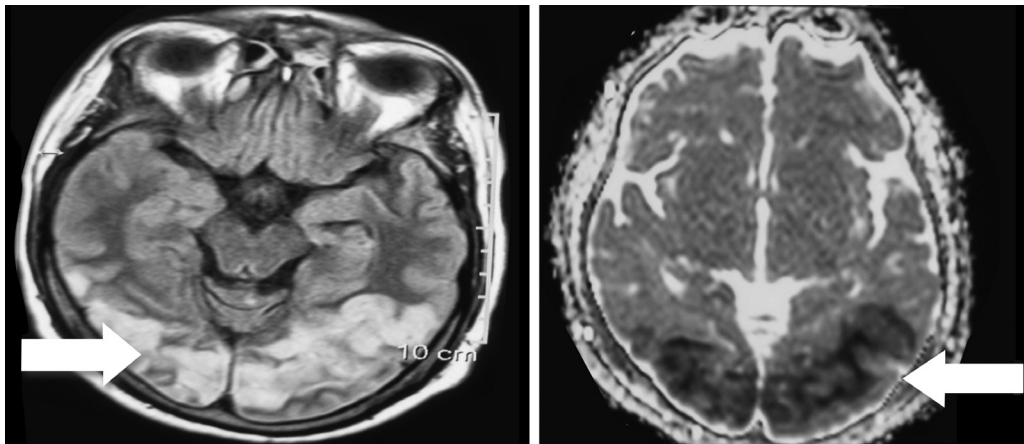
Brain magnetic resonance imaging showing infarct in bilateral occipital and left temporoparietal area, which is not limited to a single arterial territory
